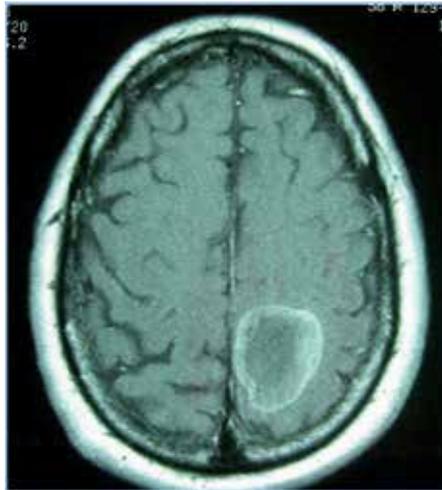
MRI showing lesion in motor cortex in a patient who presented with right sided weakness.
